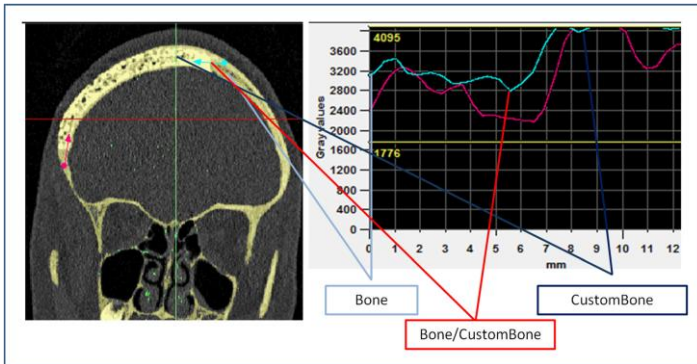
Bone density is measured using the Hounsfield Unit (HU), a quantitative scale describing radiodensity, supported by the use of Mimics software (Mimics Innovation Suite v17.0 Medical, Materialise, Leuven, Belgium), designed for the processing of 3D medical images derived from CT. Normally, bone density is greater than 1600 HU (yellow line in the graph). CBS has a density higher than natural bone (as shown in the right part of the graph). If the bone density at the host bone/custom bone interface is similar to natural bone, osteointegration is considered optimal.
